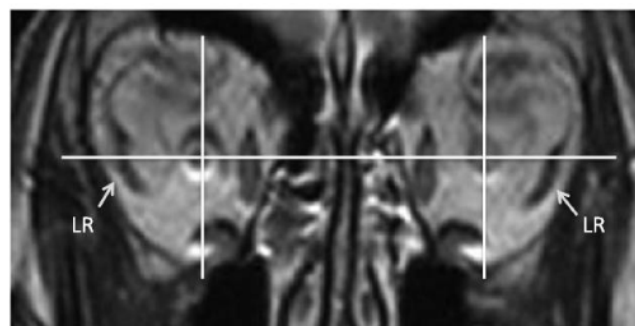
Post surgical high-resolution orbital coronal sections MRI.
